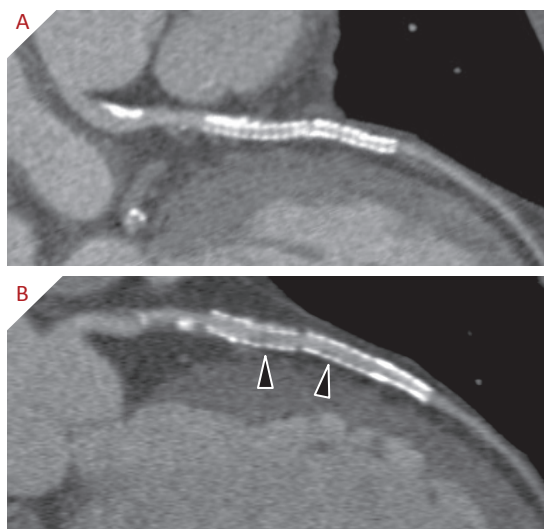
Coronary computed tomography angiography evaluation of coronary stents. Two patients, who were both evaluated for atypical complaints, already had a history of percutaneous coronary intervention. (A) Shows a left anterior descending coronary artery with two stents of a diameter of 2.75 mm. It is difficult to assess the presence of any stenosis within the stents; however, there is adequate runoff of contrast medium distal to the stents. (B) Three stents are visible in the LAD, two proximal stents of a diameter of 3.0 mm and a distal stent of a diameter of 2.75 mm. Some growth of neo-intima (arrowheads) can be assessed in both stents of 3.0 mm diameter.
